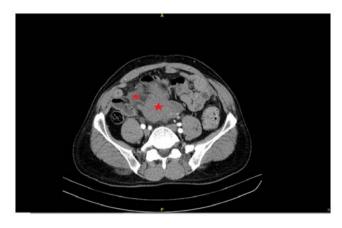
Computed tomography revealed multiple retroperitoneal masses (red stars) and intestinal wall involvement.
